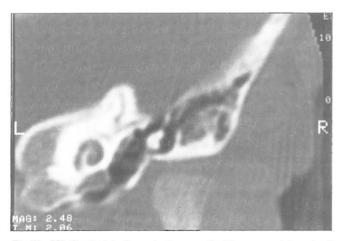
CT of patient L.: hypoplasia acoustical bones are determined directly above the head of a lower jaw.
